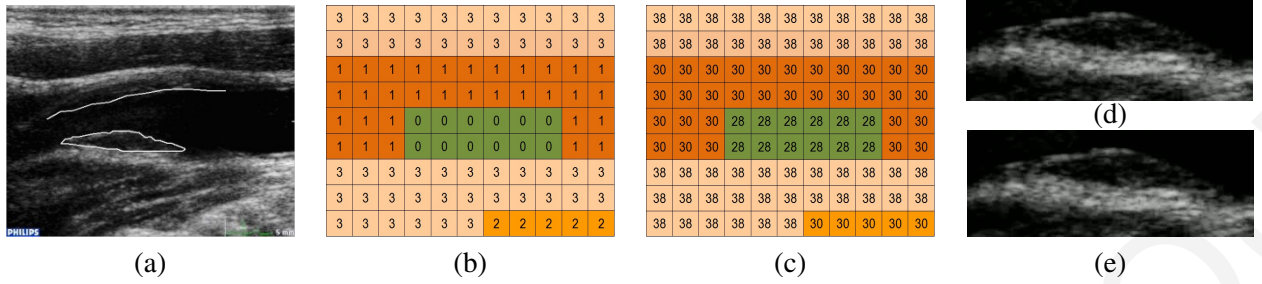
Atherosclerotic plaque ultrasound variable quality slice encoding. (a) Pixel-based segmentation of diagnostically important regions (based on [123]), (b) FMO type 2 Macroblock Allocation Map (MBAm), (c) The corresponding Quantization Parameter Allocation Map (QPAm) for variable quality slice encoding (introduced in [8]), (d) Plaque ROI segmented from original 4CIF video, (e) Plaque ROI with QP:28 segmented from 4CIF resolution video with QPs: 38/30/28.
